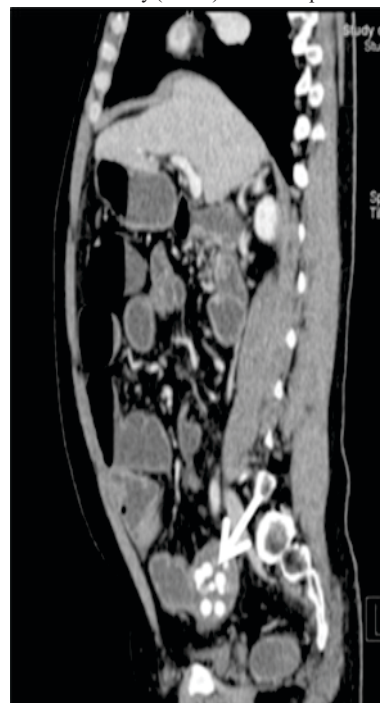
Enteroliths in ileocaecal tuberculosis. Sagittal CT image shows multiple enteroliths in distal ileum proximal to a stricture (arrow). Enteroliths are small intestinal calculi seen proximal to intestinal stasis and are rare in intestinal TB.
